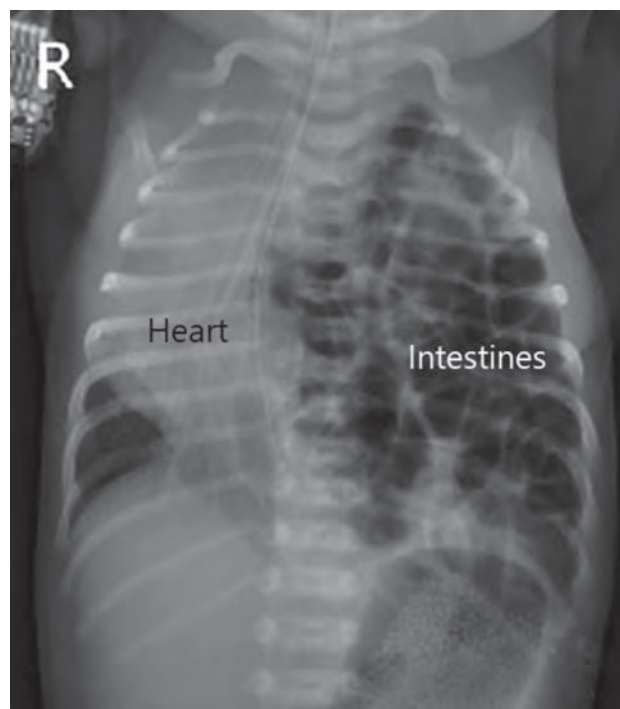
Frontal anteroposterior (AP) roentgenogram of an infant with a left-sided diaphragmatic hernia. Note the intestinal contents present in the left chest. The heart is deviated to the right chest by the herniated viscera.
